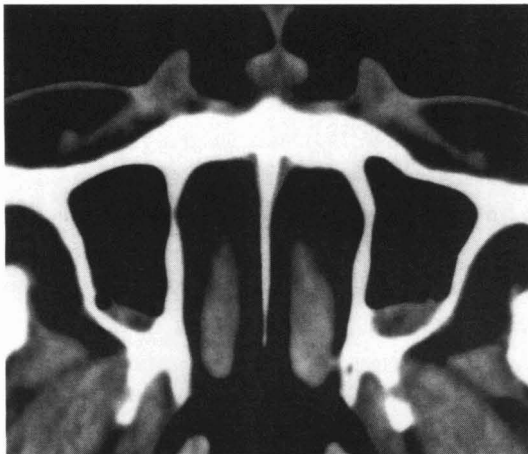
CT scan of the sinus level. Marked thickness of nasal mucosa and air-fluid level in maxillary sinuses were observed.
